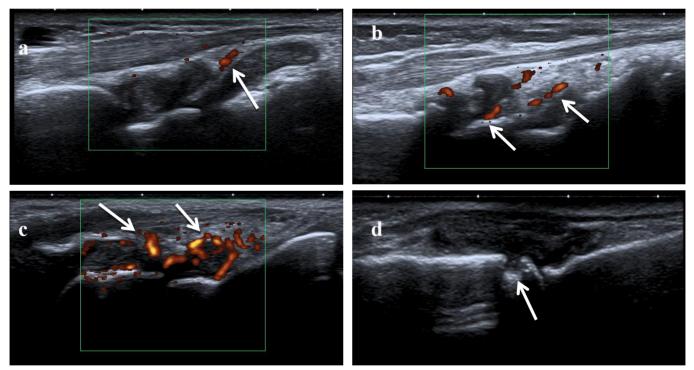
(a) Grade 1 Power Doppler signal with few vessels (one or two) in the joint, (b) grade 2: Power Doppler signal less than 50% of the synovial area, (c) grade 3: Power Doppler signal more than 50% of the synovial area, and (d) bony erosions.
